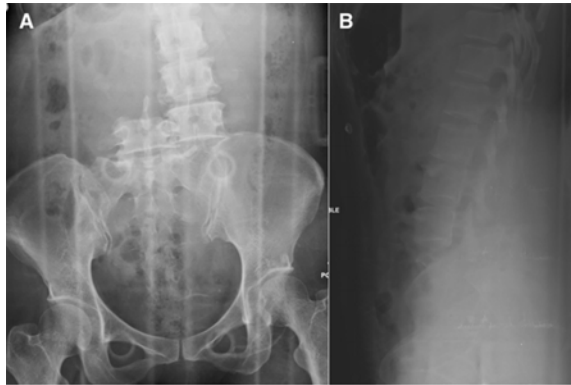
Initial plain radiographs of anteroposterior view (A) and lateral view (B) demonstrating the total L4-L5 lateral dislocation.
